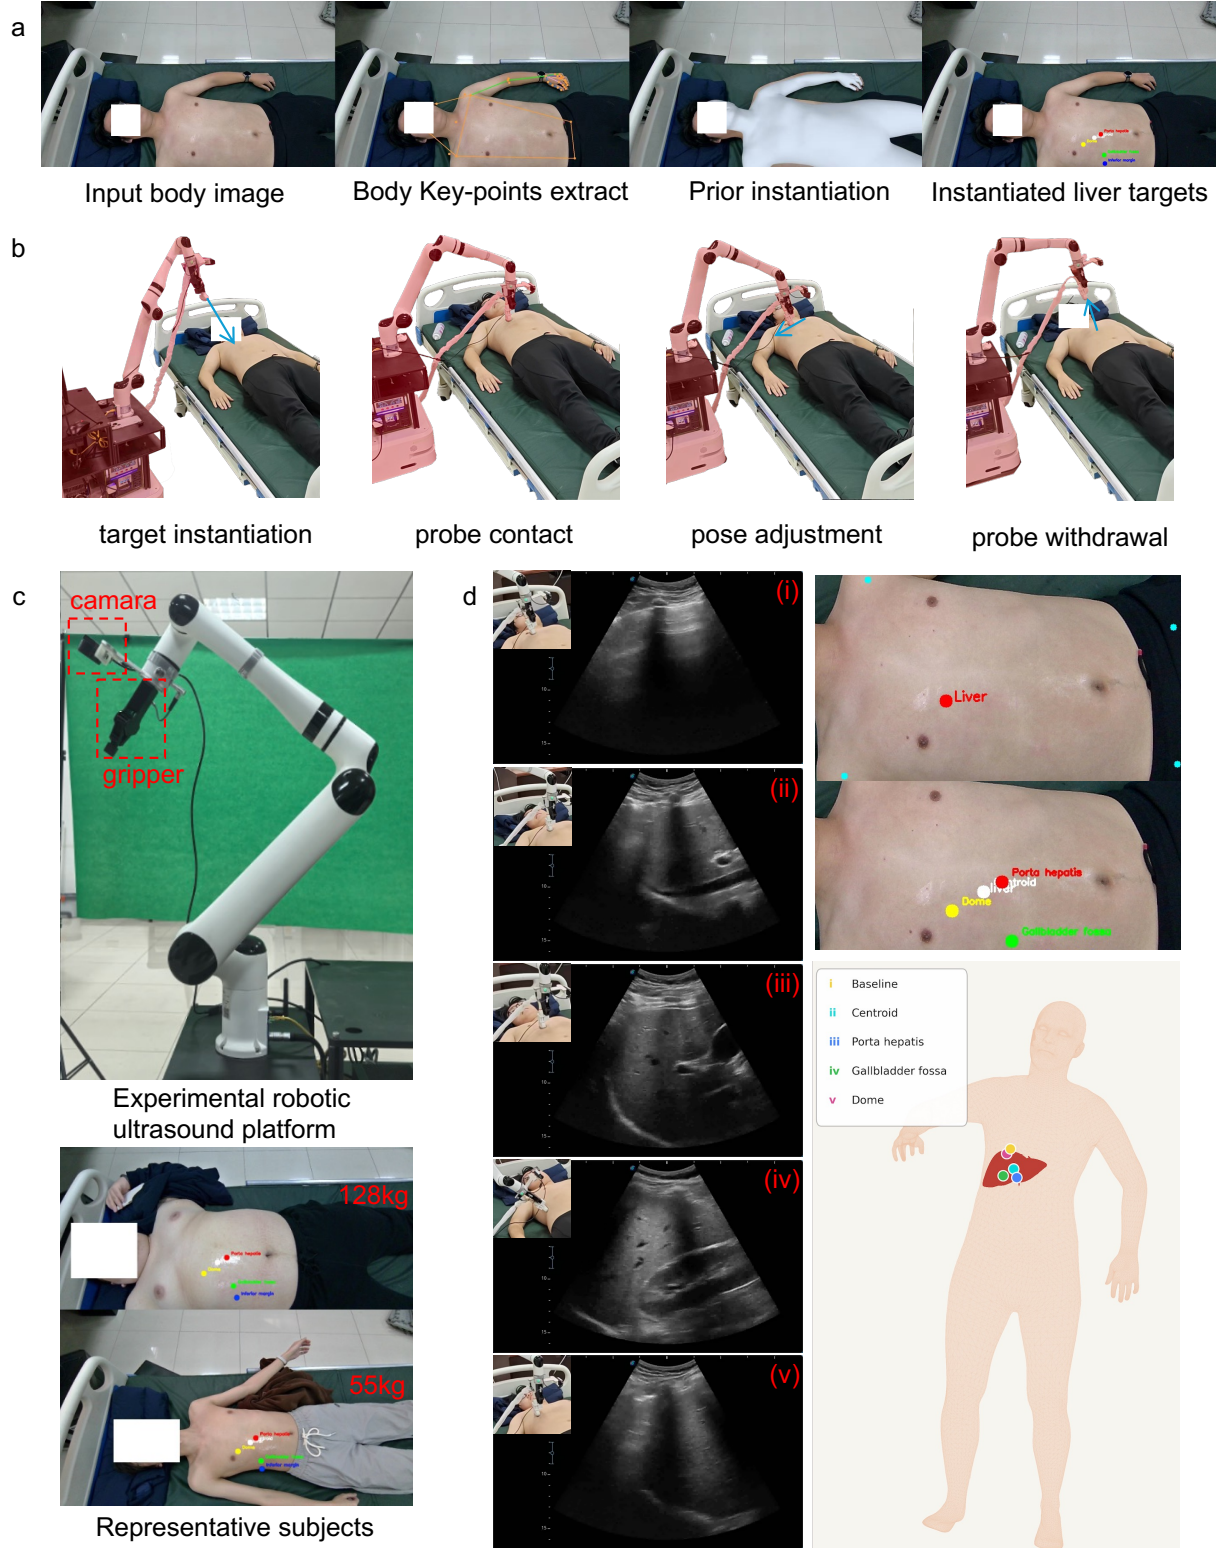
Actionable Target Initialization in real robotic ultrasound. (a) Front-end instantiation from an external body image to patient-specific liver targets. (b) Robotic execution at an instantiated target. (c) Experimental platform and representative subjects spanning substantial body-habitus variation. (d) Ultrasound returns from instantiated liver targets, establishing point-to-view correspondence between instantiated target, executed probe placement, and resulting ultrasound observation.
